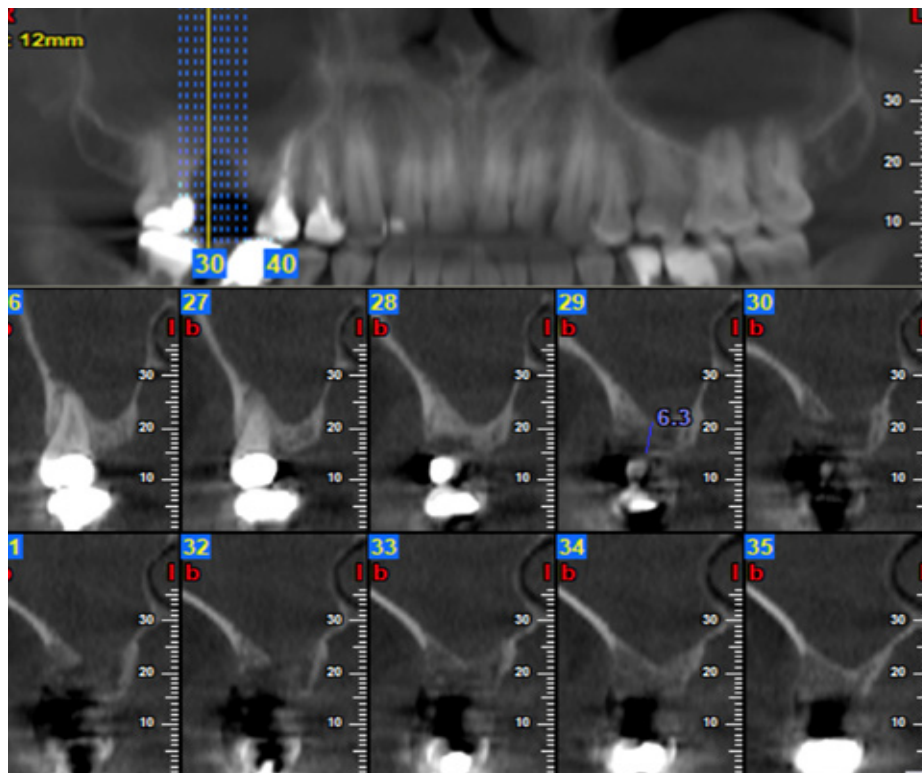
Cross-sectional views of a CBCT scan of one of the patients and their guide showing how the measurements had been done
